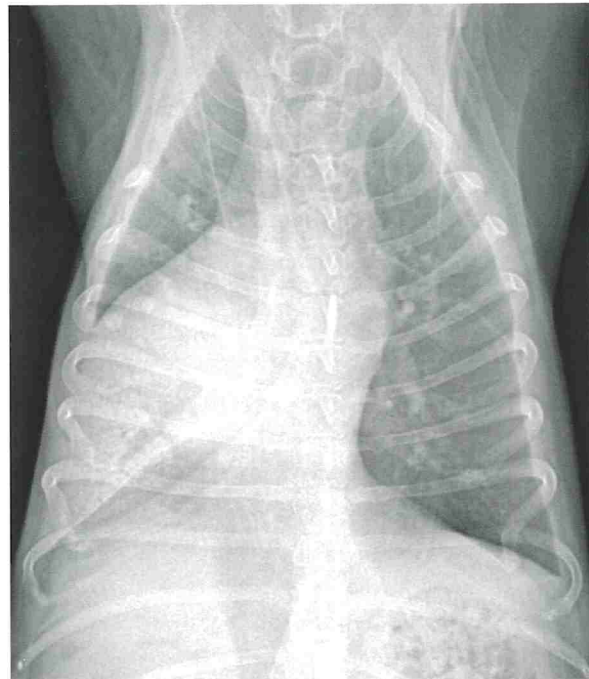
Ventralsal thoracic radiographs at the second presentation (Day 2). There was consolidation with an alveolar pattern in the right middle lung lobe. There were several bubbles within it.
